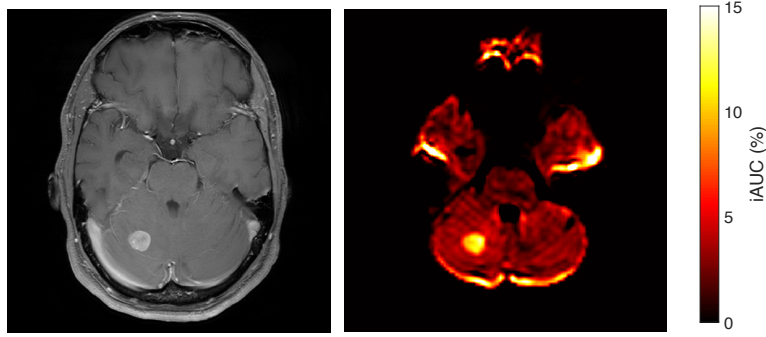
SSIFT patient data. An example patient data used to test contrast in processing schemes. The tumor is a non-small cell lung carcinoma metastatic to the right cerebellum. The lesion is conspicuous on Gd-enhanced T1-weighted image (left) and SSIFT (right).
